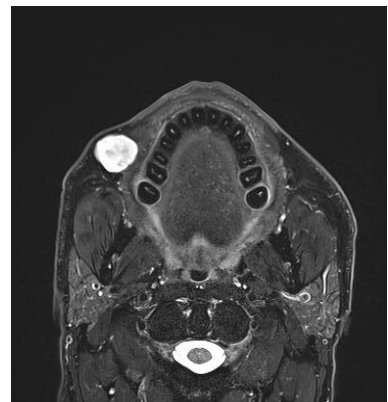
MRI-T2 Fat Sat.
